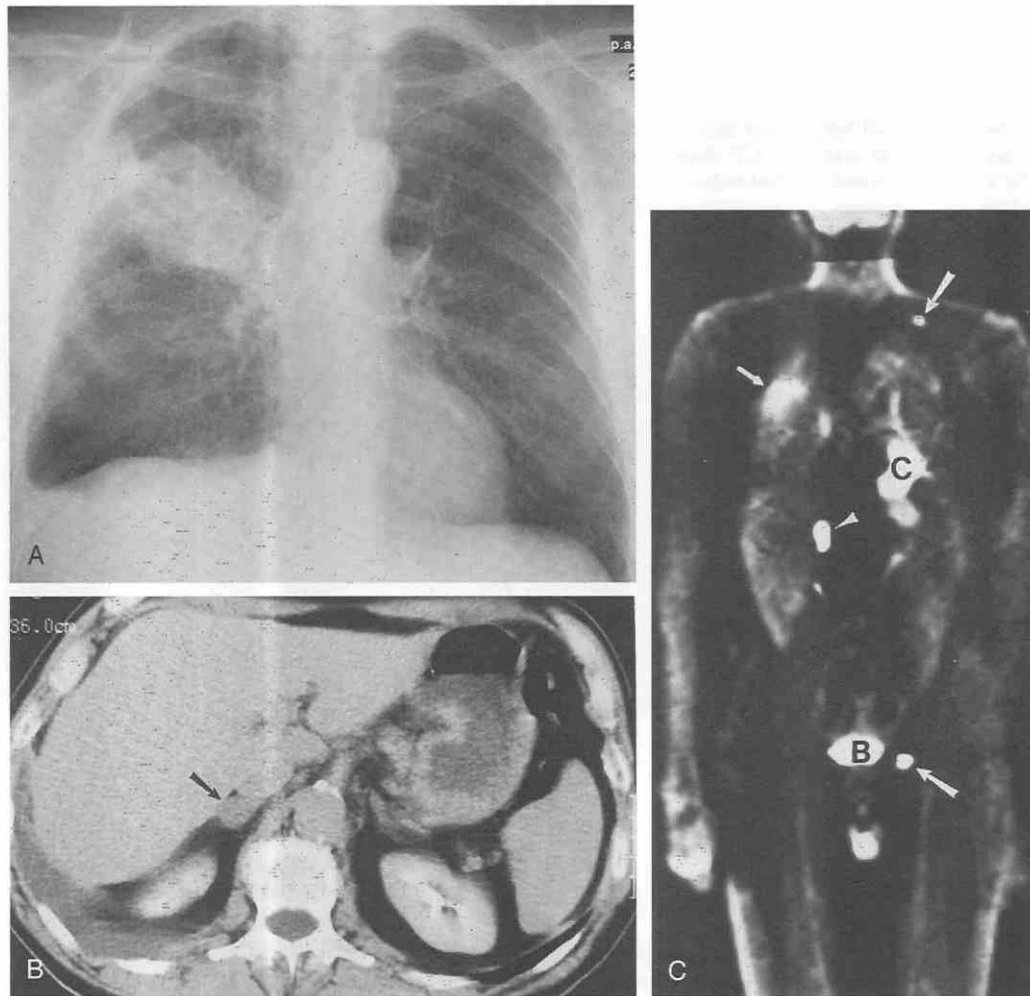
Non-small-cell lung cancer and extrathoracic metastases. *A*, Posteroanterior chest radiograph shows a right upper lobe mass. A small, right pleural effusion can be seen. *B*, CT reveals a small, right adrenal mass (*arrow*) and confirms a small right pleural effusion. *C*, Whole body PET image with ^{18}F -fluorodeoxyglucose (FDG-PET) shows increased uptake in the primary lung mass (*small arrow*) and in the adrenal metastasis (*arrowhead*). Focal areas of increased uptake in the upper aspect of the left hemithorax and pelvis (*large arrows*) were unsuspected bone metastases. B, bladder activity; C, cardiac activity.
